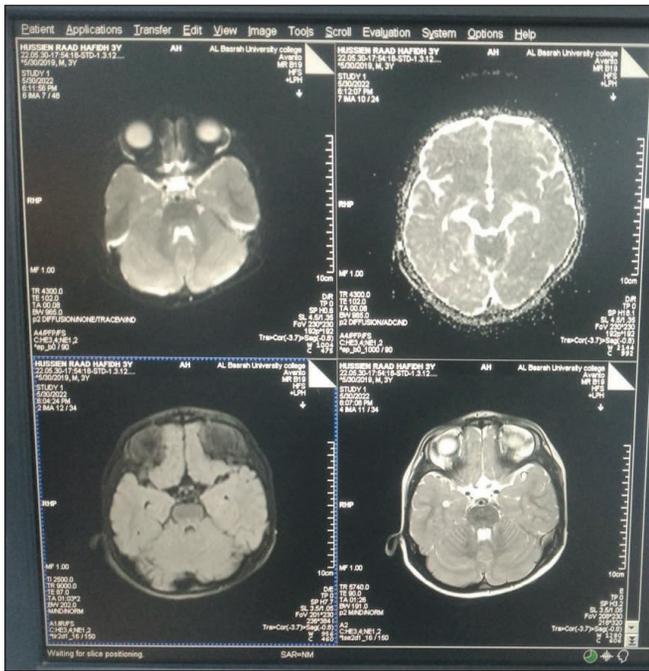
MRI completed without image distortion.
